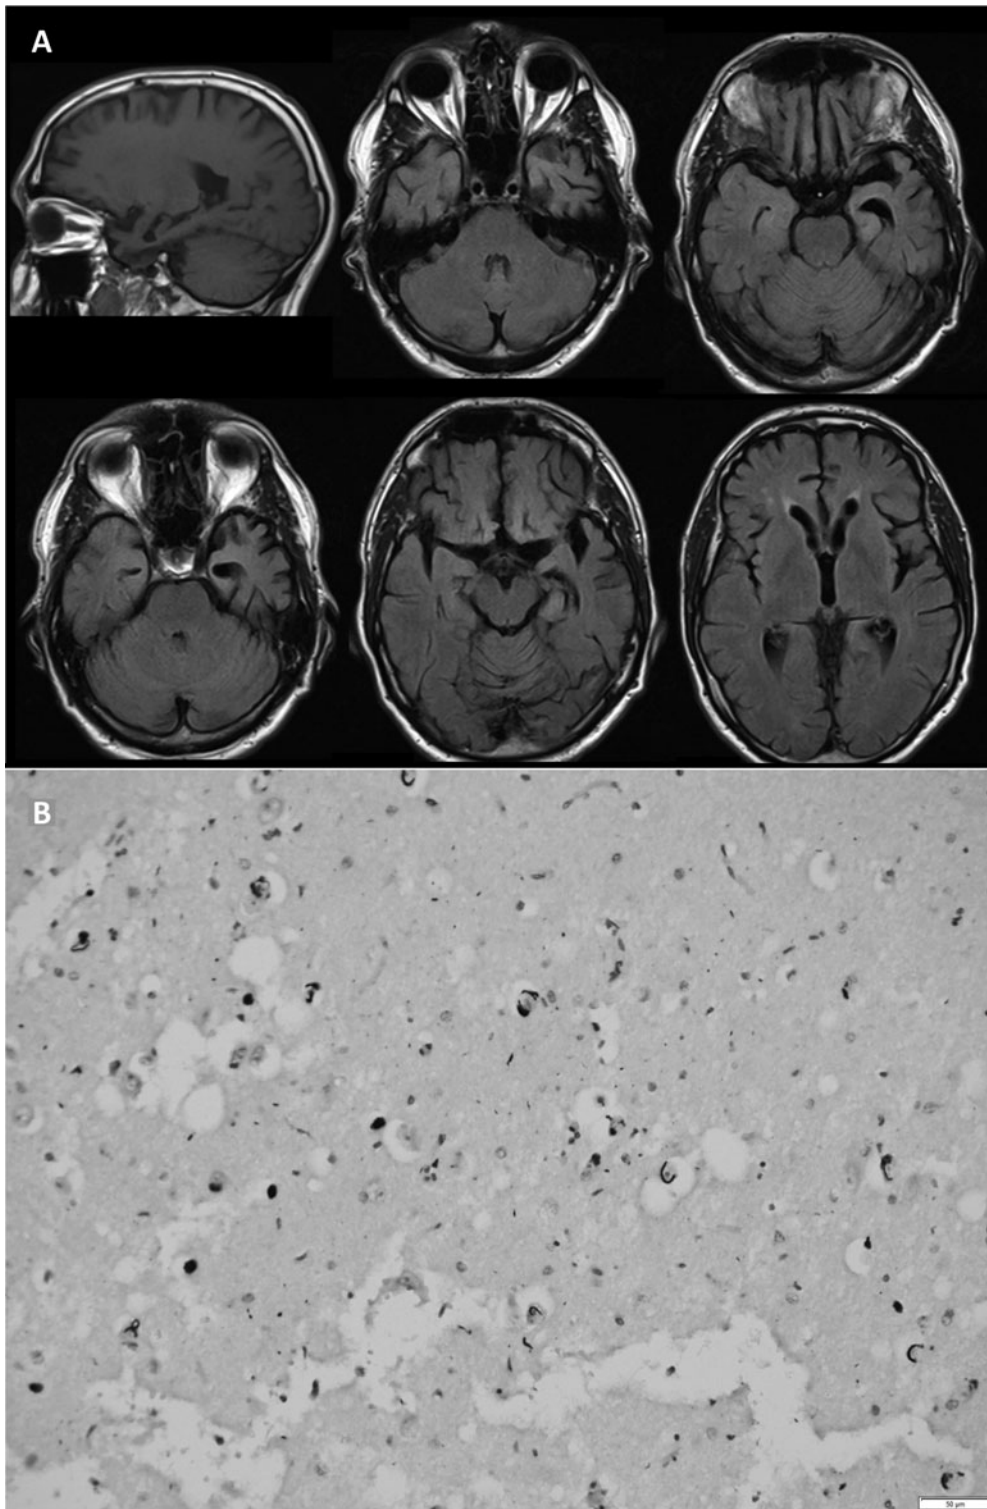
(A) T1 sagittal and FLAIR axial MRI shows focal atrophy of the left temporal lobe with dilatation of the temporal horn of the lateral ventricle. There is also atrophy of the head of the caudate nucleus. (B) Pyramidal layer of the hippocampus (CA1) showing severe neuronal loss and gliosis with positive ring-like FUS inclusions within neurons and within the neutrophil. (FUS immunoperoxidase $\times 200$).
